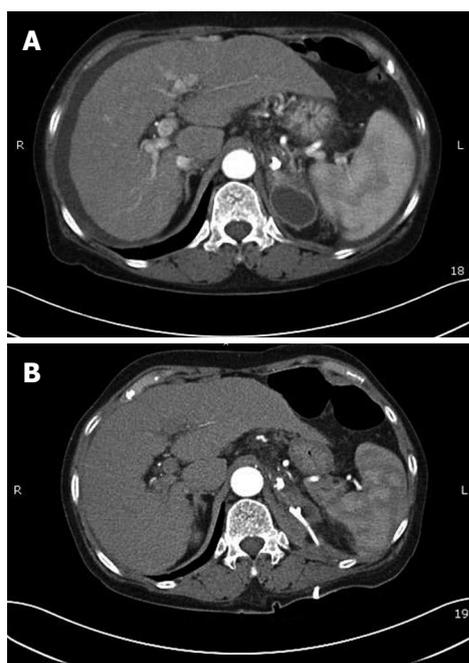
Adrenal abscess after Histoacryl® injection. A: Computed tomography scan showing adrenal abscess after Histoacryl® injection; B: Adrenal abscess was resolved after PCD insertion.
